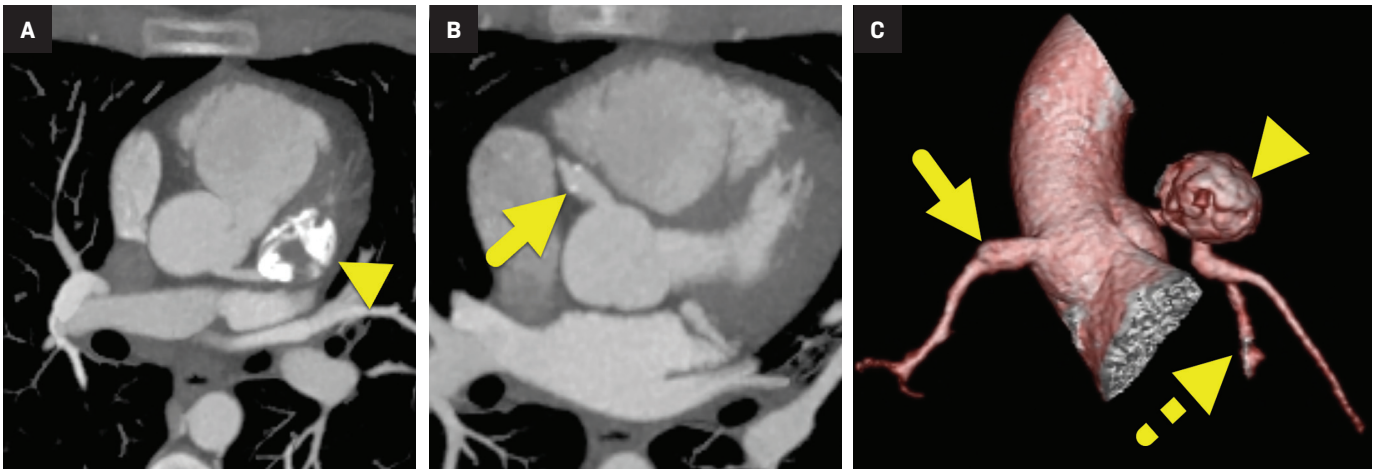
Cardiac CT axial maximum intensity projection image at the level of (A) the left main coronary artery and (B) the right main coronary artery shows a thrombosed aneurysm (arrowhead) at the origin of the LAD coronary artery and a fusiform aneurysm (arrow) of the RCA. (C) 3D reconstructed image shows an aneurysm (arrowhead) of the left anterior descending coronary artery. Fusiform aneurysms are present arising from a branch of the left circumflex coronary artery (dashed arrow) and right coronary artery (arrow).
